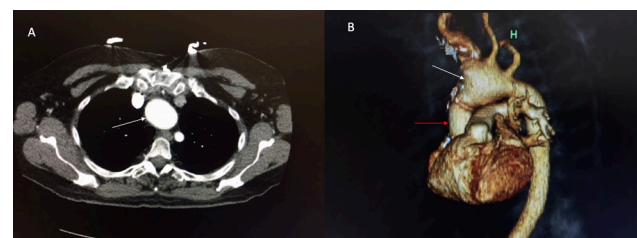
Panel A showing a preoperative multi-detector axial computerized tomographic (CT) image with a white arrow pointing to the aortic arch aneurysm. Panel B showing a preoperative 3D reconstruction image with a white arrow pointing to the aortic arch aneurysm, and a red arrow pointing to the pre-existing ascending aortic graft.
